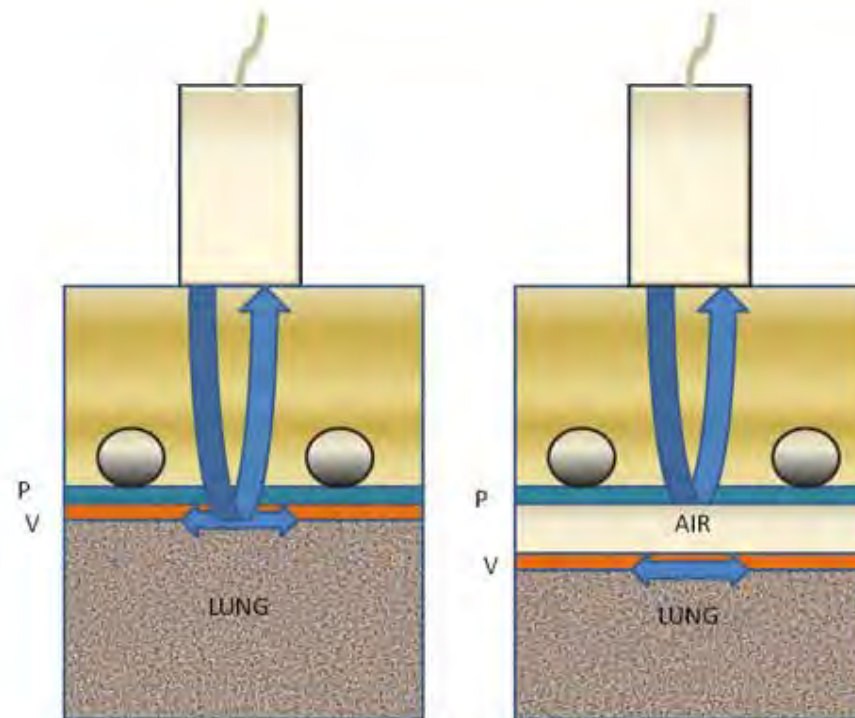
Ultrasound waves are reflected back at the visceral pleura-lung interface – pleural sliding can be seen (a). In the presence of a pneumothorax, ultrasound waves are reflected at the parietal pleura – air interface and no sliding is seen (b).
